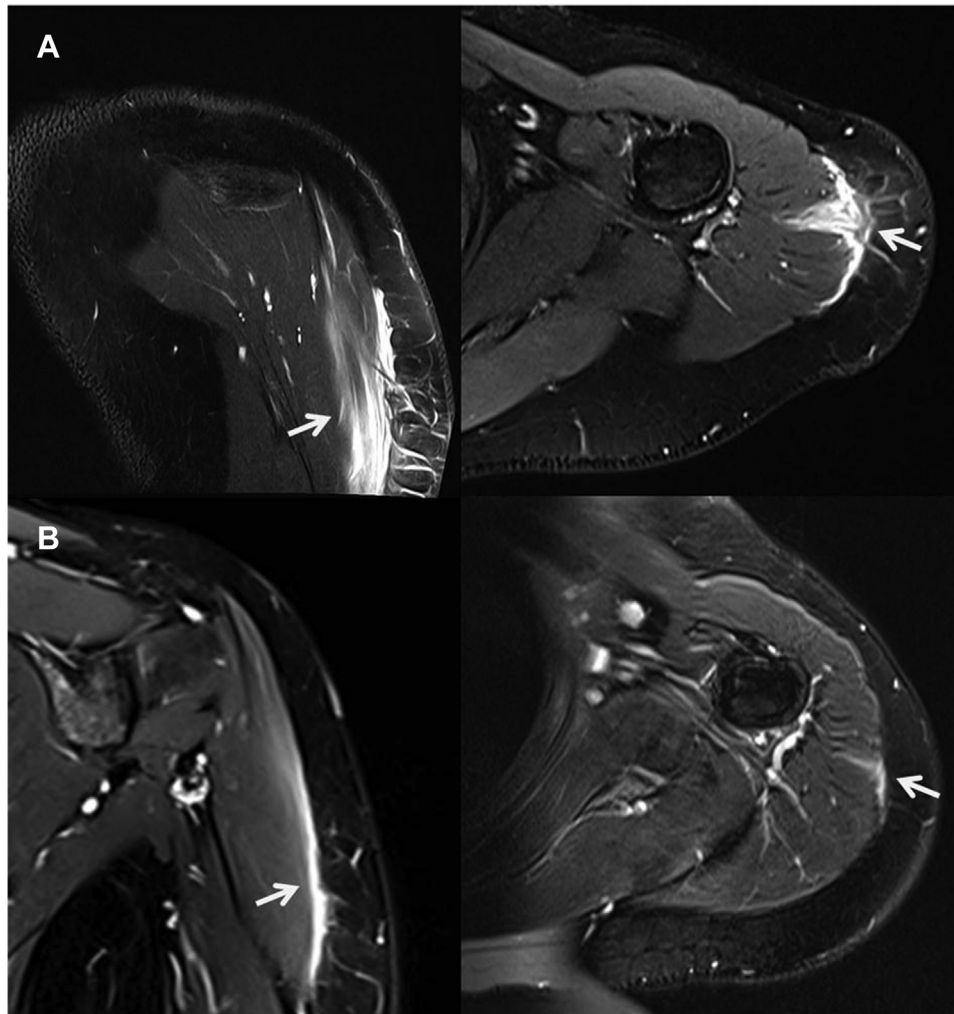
Case 1. (A) The MRI presented edema in the left deltoid muscle and superficial soft tissue, and fluid signal (about 120 mm length) on the T2-weighted image. (B) After 1 month, the range and intensity of the fluid signal on the T2-weighted image were decreased compared with the previous MRI. MRI, magnetic resonance image.
